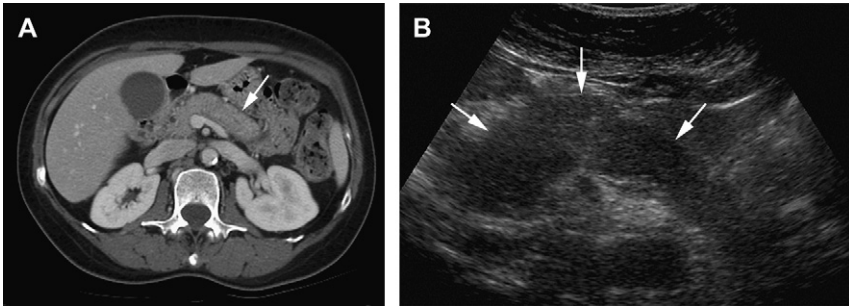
Images from a 43-year-old woman with history of abdominal pain. (A) Contrast-enhanced CT shows an absence of normal pancreatic lobulation and subtle peripancreatic low attenuation (arrow). (B) Transabdominal ultrasound shows global pancreatic enlargement (arrows).
